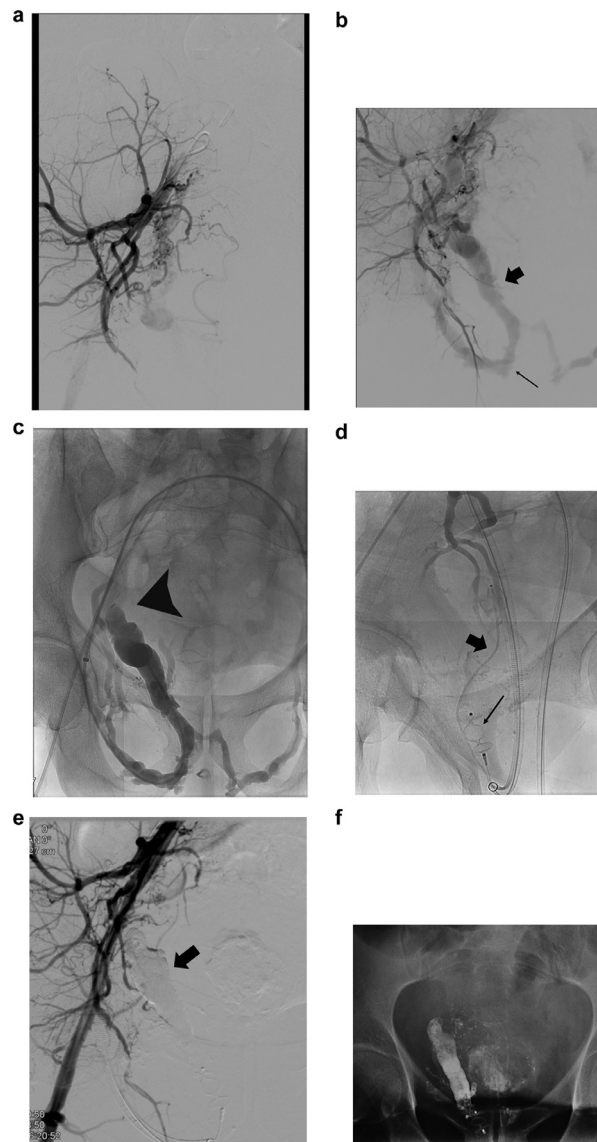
Patient with a pelvic AVM complicated by an acute hemorrhage (hematuria) following a transurethral resection of the prostate. The patient was first embolized urgently with glue injection in both prostatic arteries followed by gel foam injection in the anterior trunk of the right internal iliac artery. Bleeding recurrence was observed 5 days later. (a,b) DSA acquisition after opacification of the right internal iliac artery showing a type II Cho and IIIa Yakes AVM with retrograde venous drainage through the internal pudendal (large arrow) and obturator vein (small arrow). (c) Catheterization of the right obturator and internal pudendal veins through contralateral approach after catheterization of the external pudendal vein via the right common femoral. A proximal occlusion of the right internal iliac vein (arrowhead) is observed, explaining the retrograde drainage and the venous congestion causing the hemorrhage. (d) Deployment of an Amplatzer plug (small arrow) in the central portion of the obturator vein combined with a coaxial insertion of a microcatheter (large arrow) in the peripheral internal iliac vein. (e,f) Control DSA (e) and plain film (f) after embolization of the vein with STS foam followed by occlusion with Glue (arrow). Complete occlusion of the AVM is observed on the DSA.
